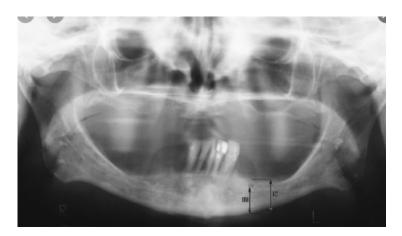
Panoramic radiography of a severely reduced residual ridge in both maxilla and mandible
